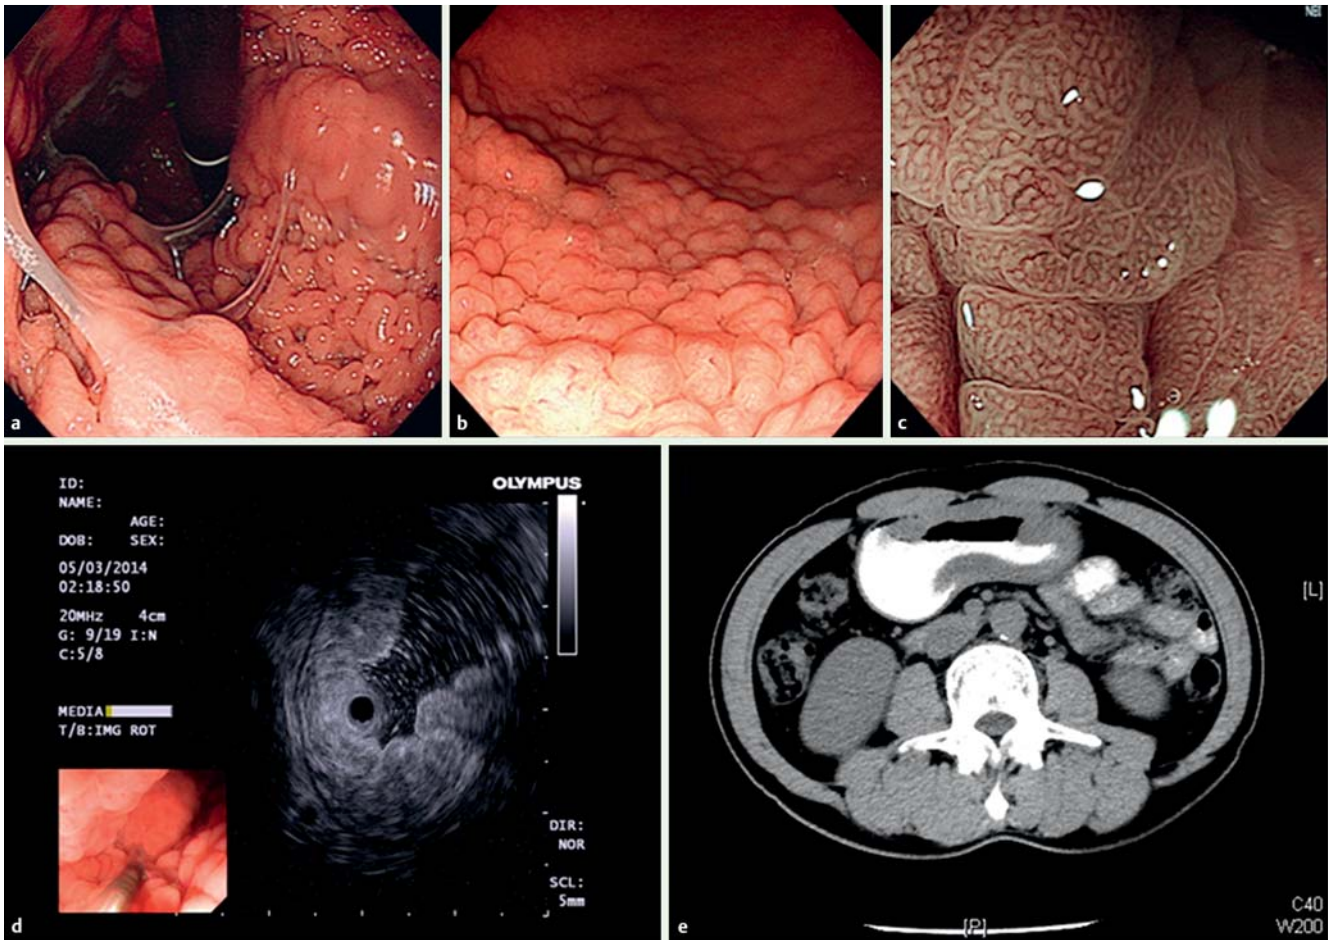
Ménétrier's disease. a, b Endoscopic views of the stomach under white light. c Narrow-band imaging of the hypertrophic mucosa. Ultrasonic (d) and computed tomographic (e) views of the stomach.
